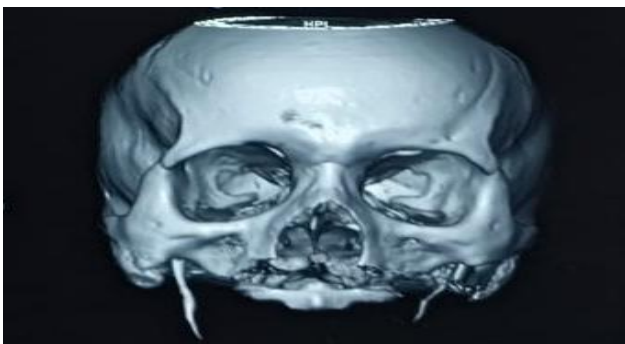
Pre op 3D CT scan of face.
